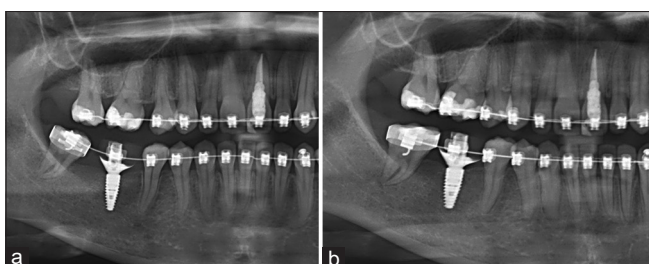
Panoramic radiograph. (a) After 3 months of the dental implant insertion, a good osteointegration around the fixture was obtained. The provisional crown was loaded thereafter. (b) The lower right premolars were retracted and the lower right third molar was protracted with good periodontal health.
